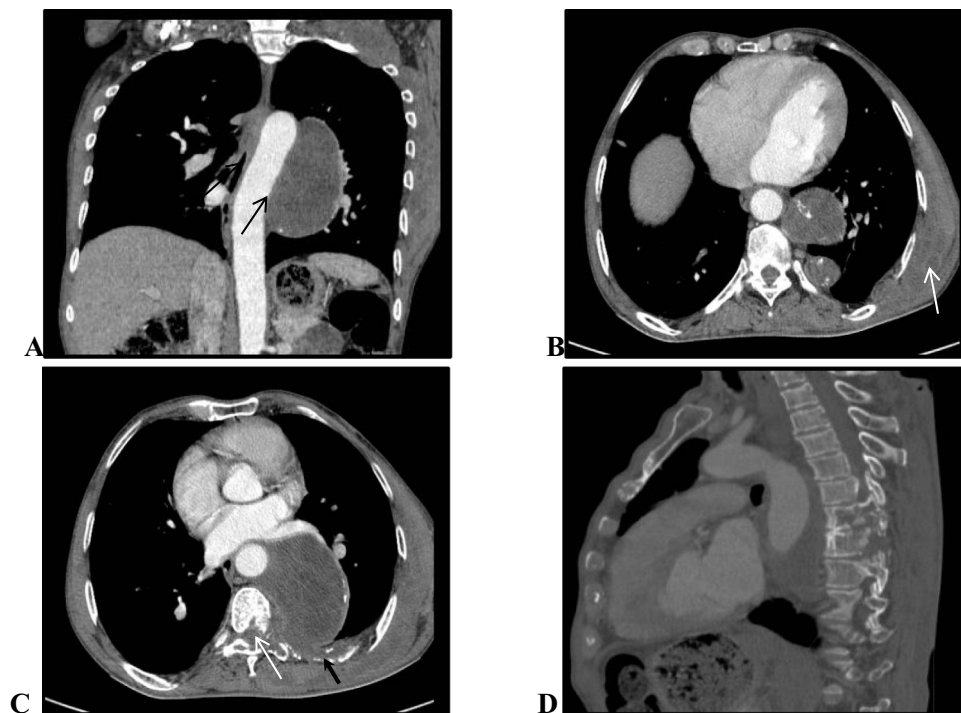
Coronal image reconstruction shows the close relationship between the cyst and descending aorta (black arrow) (A). Axial, post-contrast CT images at T5 level show chest wall asymmetry with multiple cystic lesions, with minimal wall enhancement (white arrow) (B). Axial Mediastinal window and sagittal bone window reconstruction show lytic lesions of posterior vertebral body, left pedicle and transverse process with adjacent ribs seen (short black arrow). There is widened left side neural foramen and perineural fatty effacement (white arrow) (C and D).
